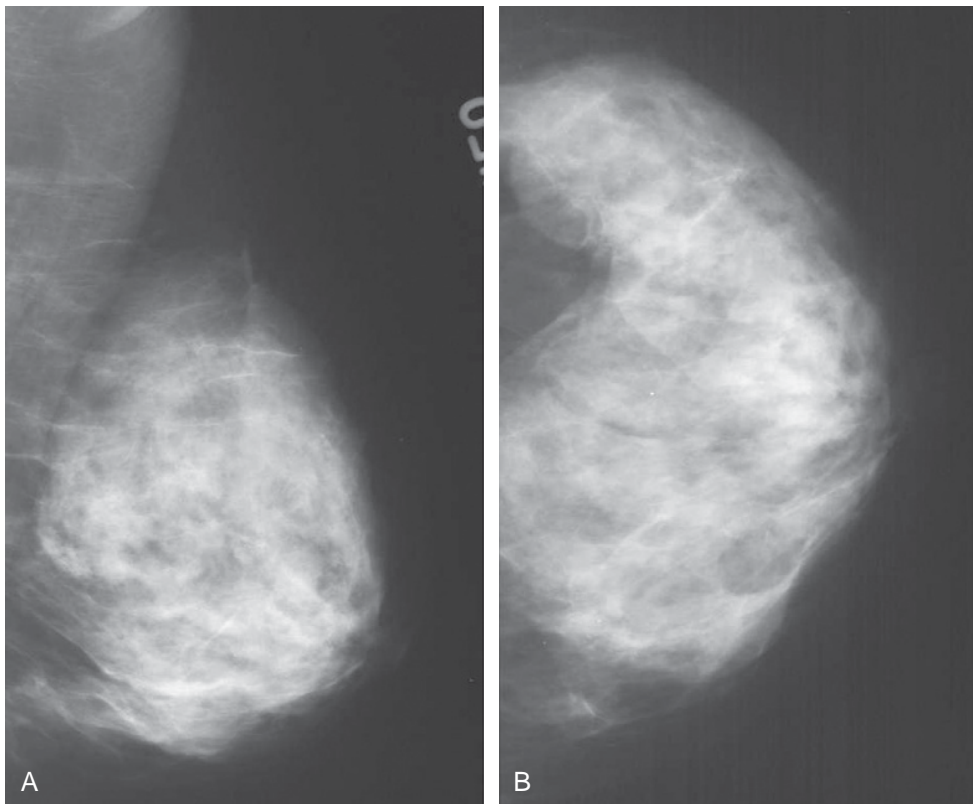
The MLO view (A) compresses the breast along a plane of approximately 45 degrees extending from the upper inner quadrant to the lower outer quadrant, with the x-ray tube rotated parallel to the pectoralis muscle fibers. When done properly, the MLO view shows both axillary tail and abdominal wall. The CC view (B) positions the breast directly on top of the x-ray cassette holder, with the x-ray tube positioned for superior to inferior imaging. The CC and MLO views of the right breast are negative for malignancy. (Image courtesy of Dr. Alexis Nees, Department of Radiology, University of Michigan.)
